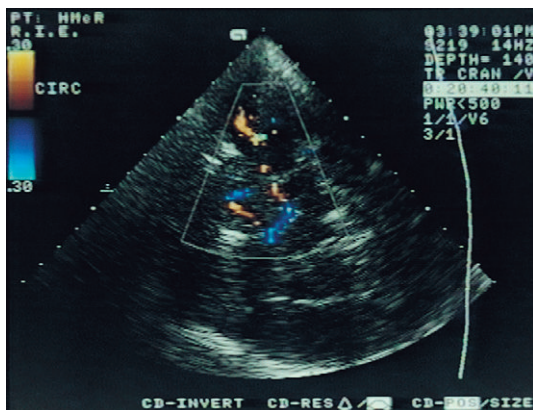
The anterior and middle cerebral arteries on transcranial colour Doppler ultrasound through the transtemporal window.
